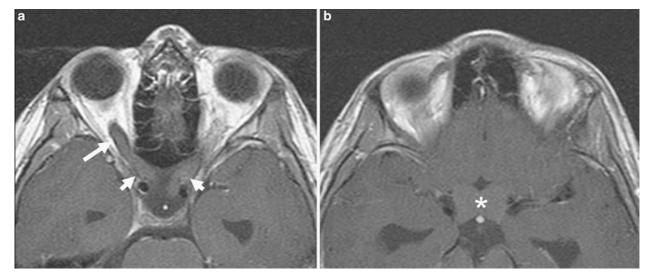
Brain MR images from a patient with neurofibromatosis type 1. At the age of 9 years his first brain MRI was obtained (ordered to work-up attention deficit disorder), and revealed glioma involving posterior intraorbital optic nerve on the right, bilateral intracanalicular and intracranial optic nerves, and chiasm. Serial MRI's performed on a yearly basis over the ensuing 8 years revealed no change in the extent of the glioma. Serial eye exams during this time period also revealed stable findings; visual acuity 20/70 + OD and 20/60- OS, Lisch nodules, and symmetric temporal optic pallor OU. The patient received no treatment for the glioma. (a, b) T1-weighted post-contrast axial brain MR images obtained when the patient was 9 years old. (a) Image shows glioma involving the right intraorbital optic nerve (long arrow), and bilateral intracanalicular and intracranial optic nerves (short arrows). (b) Chiasm is diffusely enlarged due to glioma (asterisk).
